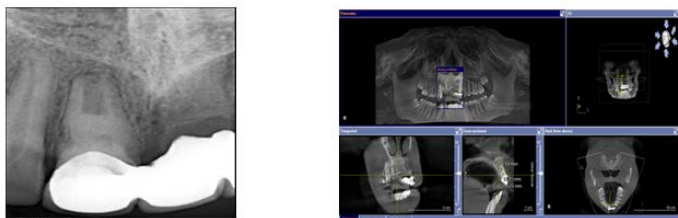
Twelve months follow up Fig 22: Post-Op CBCT
